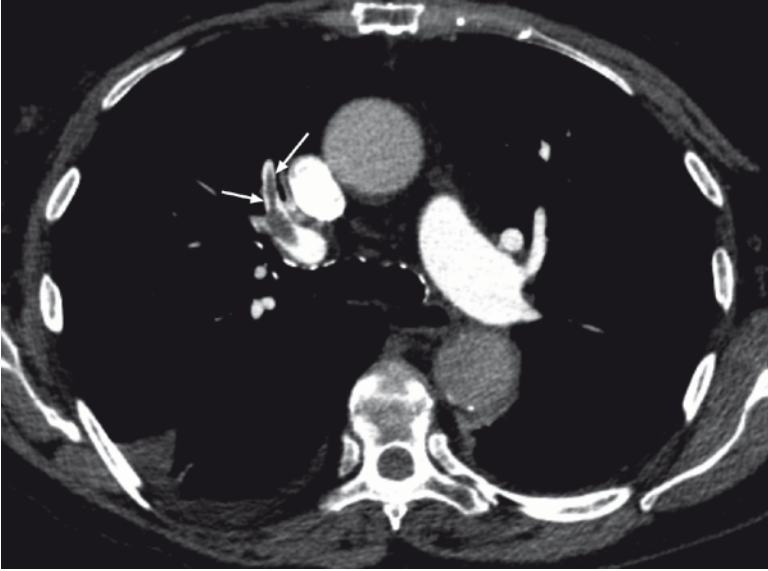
Axial CTPA image. A nonocclusive thrombus with contrast media seen to pass either side of the thrombus (*white arrows*); the CT equivalent of the angiographic railway track sign
